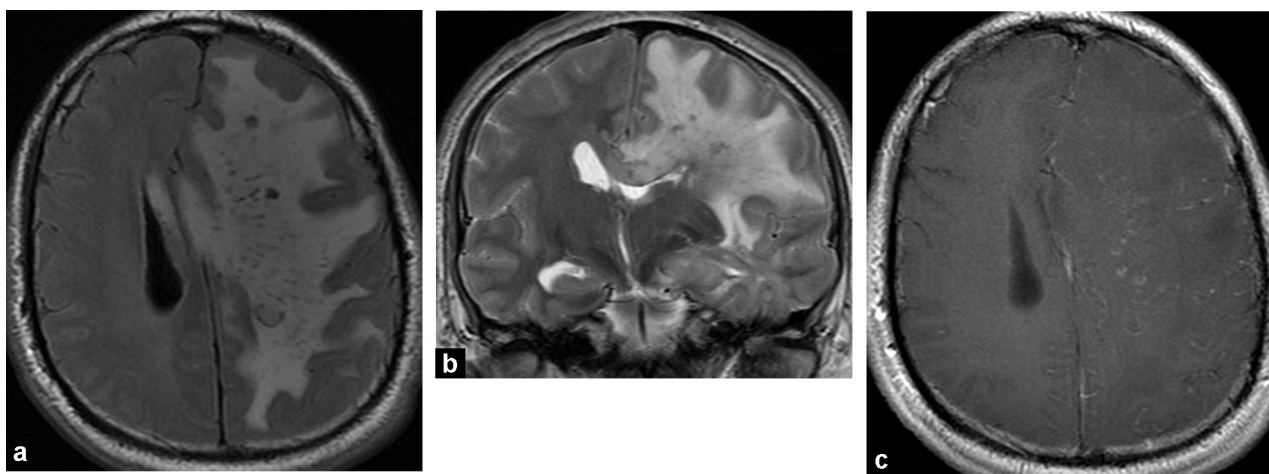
Primary cerebral vasculitis. FLAIR axial (a), T2 coronal (b) and T1 axial after injection of gadolinium (c). Vast range in T2 hypersignal and FLAIR, reaching the left cerebral hemisphere with moderate heterogeneous enhancement and multiple micro bleeding, visible in hyposignal in T2 and FLAIR. Significant perilesional oedema and mass effect with subfalcine and left temporal engagement.
